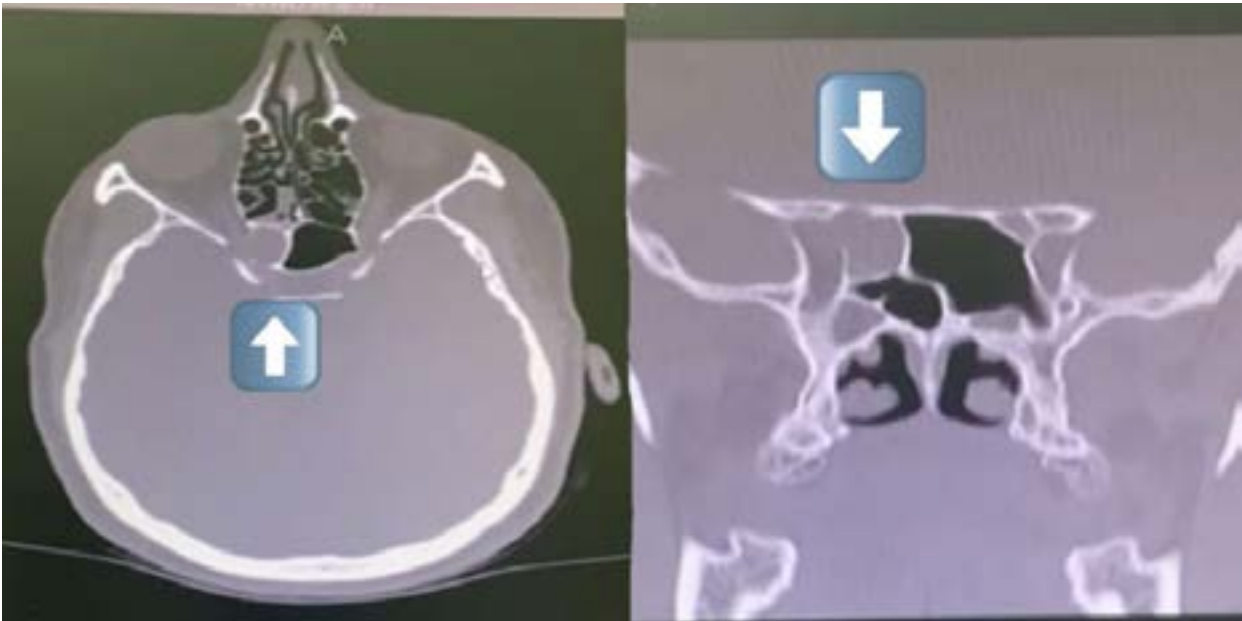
CT scan showing right sphenothmoidal cell (Onodi cell) opacification and other features of pansinusitis.
